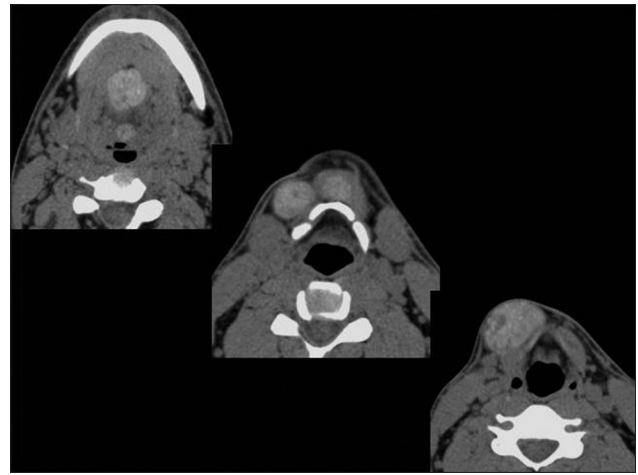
Axial plain computed tomography scan demonstrating well defined rounded hyperattenuating lesions at the base of the tongue, sublingual, prehyoid and right lateral cervical submandibular region
